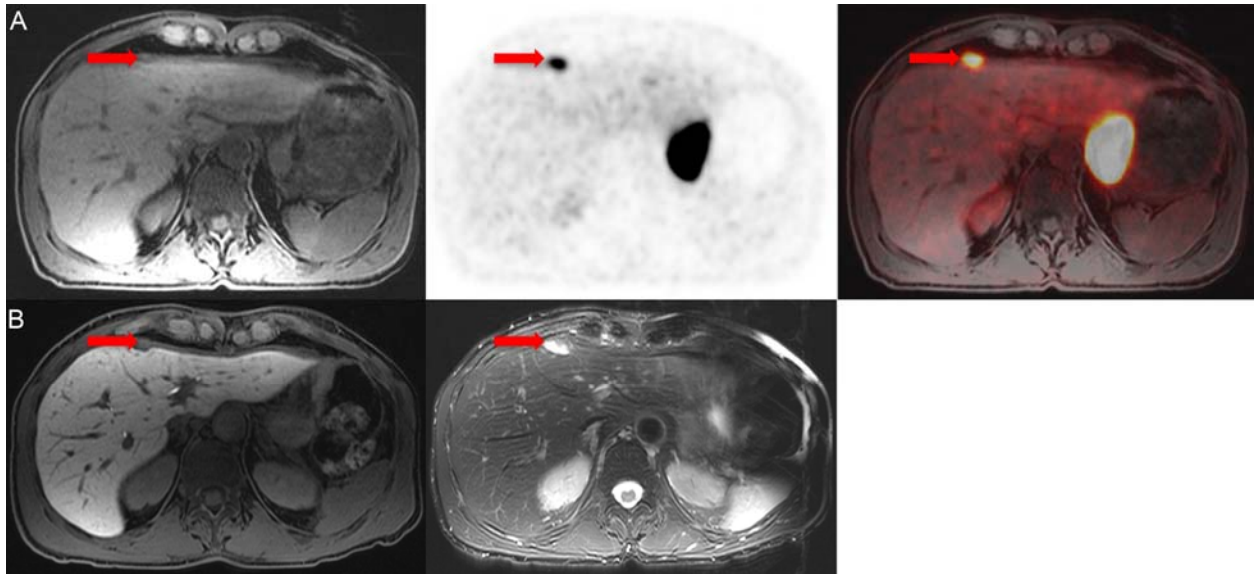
65 year-old man (participant #23) with PCa treated with radical prostatectomy, radiation therapy and androgen blockade at initial presentation (Gleason 3+5), now with BCR since 2014 and rising PSA (from 0.72 to 3.4 ng/ml at time of the scan). (A) Transaxial ^{68}Ga -RM2 PET images and fused PET/MRI. MRI did not identify an anatomical lesion. (B) Follow-up MRI done *4 months later* indicate a lesion that was biopsy-proven to represent metastatic adenocarcinoma of prostate origin.
